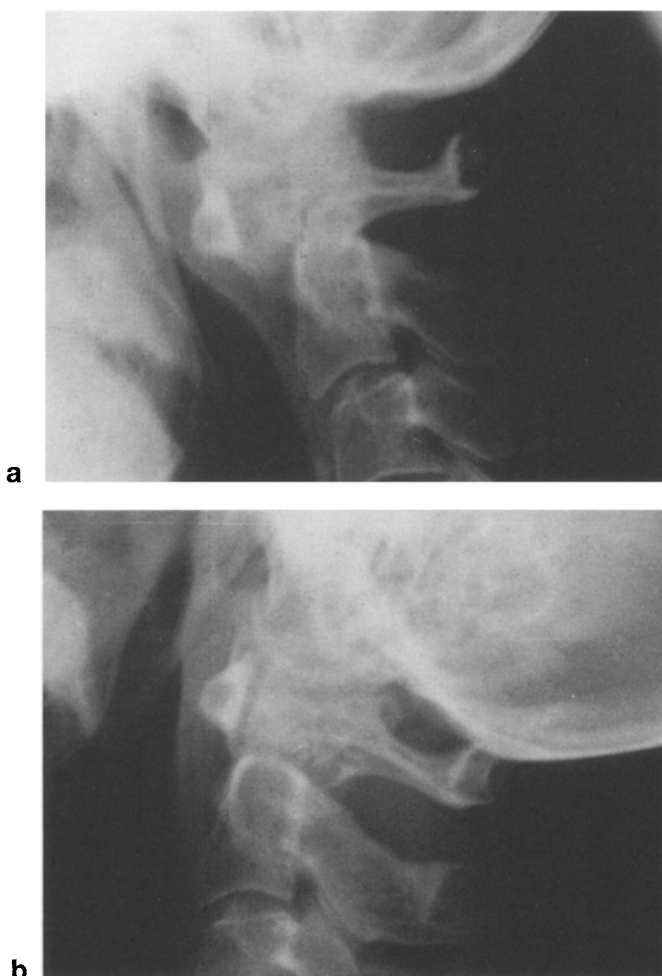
(a) Lateral view radiography taken during flexion. A 9 mm atlantoaxial subluxation is seen. (b) Lateral view radiography taken during extension demonstrates reduction of the atlantoaxial subluxation. On a neutral lateral radiograph, the atlantoaxial distance could be the same as in flexion, extension, or somewhere in between.
